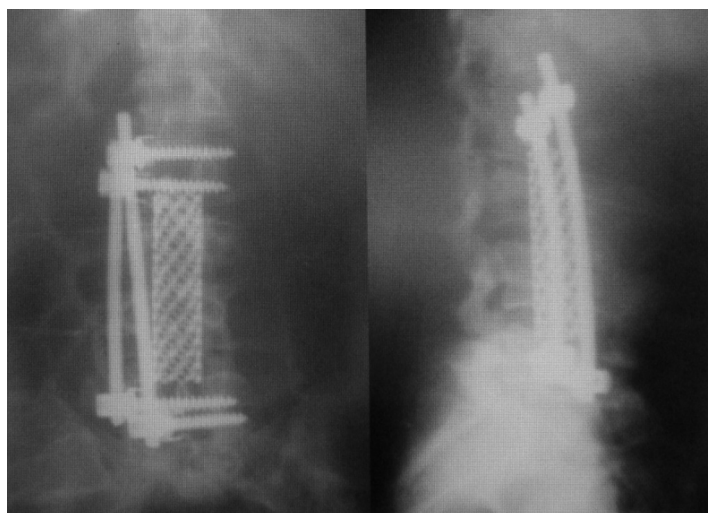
Postoperative radiographs. Plain anteroposterior and lateral view of the lumbar spine, postoperatively taken in the same patient depicted on figure 1. The patient was operated anteriorly by radical debridement, anterior reconstruction with mesh cage and bone graft, and rigid anterior instrumentation.
